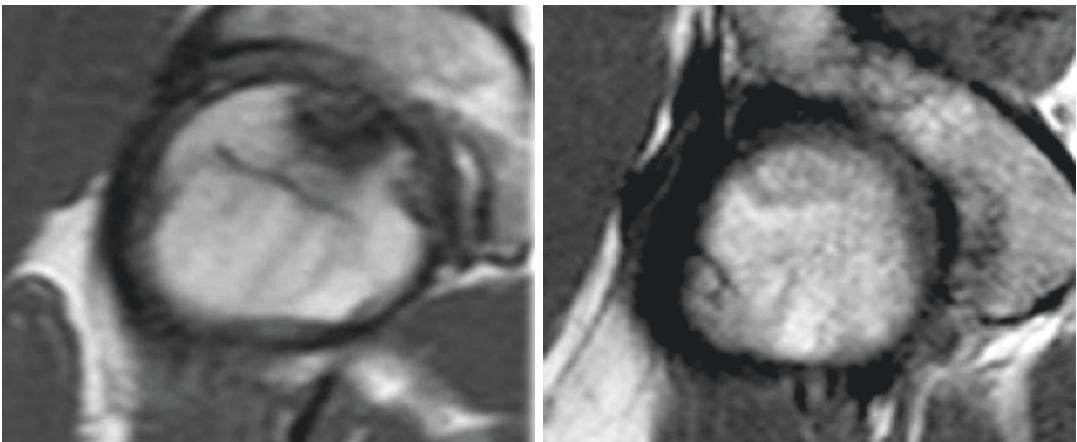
Left:* MRI showing the femoral head defect. *Right:* The defect is no more visible 18 months after the arthroscopic procedure
